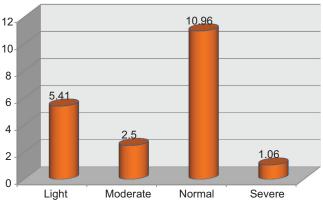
Mean value of T2 scores based on MRI T2 grading
